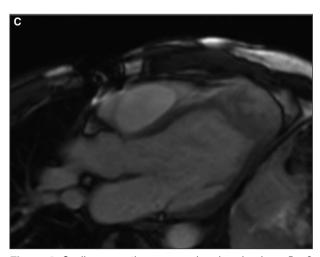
Cardiac magnetic resonance imaging showing a 5×3 cm hypo-intense lesion with pericardial involvement and apex compression in echo gradient sequences in the four (A) and two-chamber (B) axis that also shows heterogeneous gadolinium enhancement (C).
